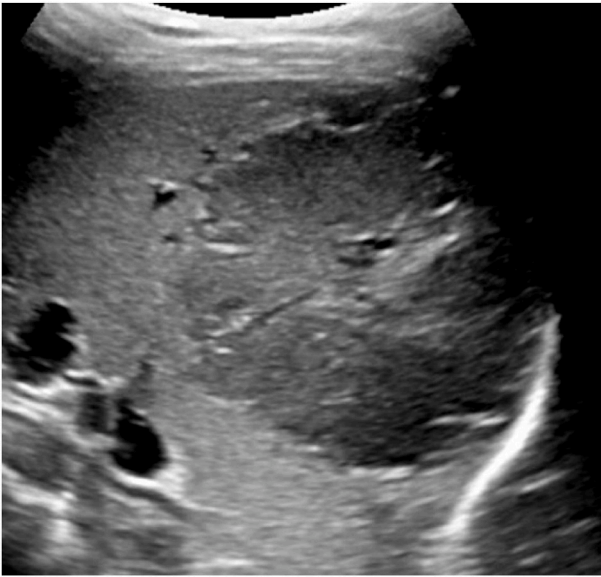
Mass as seen on ultrasound.
